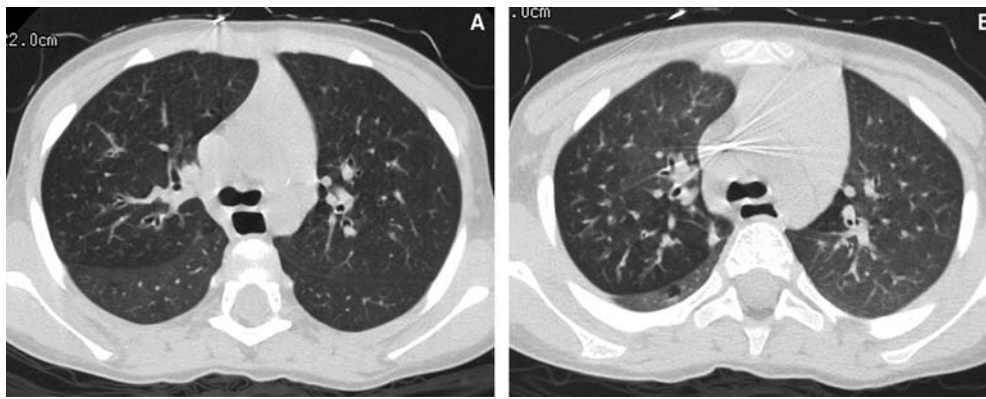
The controlled ventilation technique as applied to CT imaging of the chest of a 2-year-old with CF. Inspiratory (A) and expiratory (B) views demonstrate excellent spatial resolution in this sedated young child. Mild airway thickening is noted in several airways. The expiratory view demonstrates air trapping in the posterior segment of the right upper lobe. (Reproduced courtesy of Frederick R. Long, M.D.)
